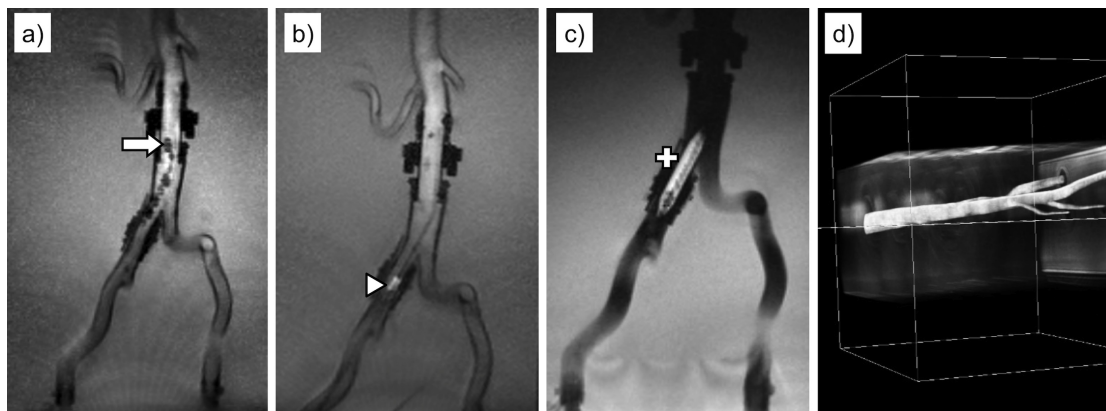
MR images of device placements in the common iliac artery obtained with the developed real-time interface and customised interventional protocol - image (a) shows the tip section of the MRI-safe guidewire (the arrow indicates the tip) with the susceptibility artefacts of each distinct passive marker. Image (b) displays the straight catheter with the resonant tip marker (arrowhead) at the level of the iliac arteries. On image (c) the inflated balloon catheter ('+') with 1:100 Gd-doped saline solution, positioned in the right common iliac artery, can be depicted. Image (d) demonstrates a post-interventional MIP of a 2D ToF MRA with treated stenosis in the right common iliac artery.
